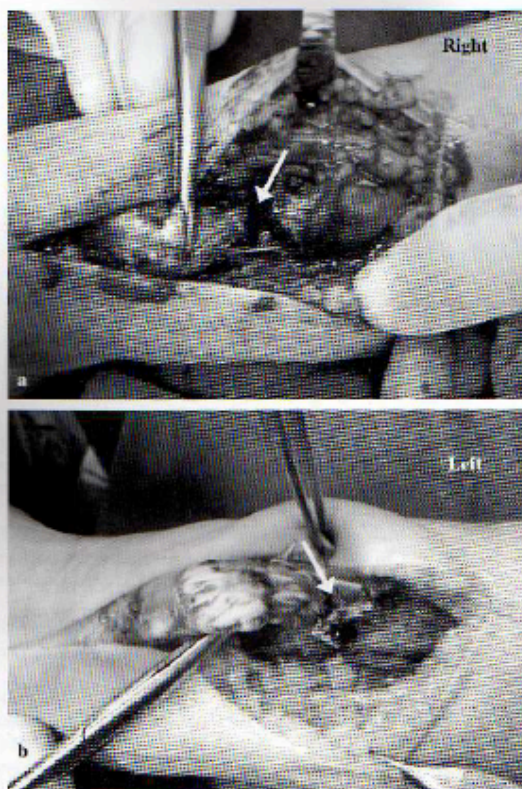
Complete rupture of the Achilles tendons. a Left tendon. As discovered using sonography, there was remarkable retraction of the rupture ends (*arrow*). b Right tendon. As discovered using sonography, there was little diastasis between the rupture ends
